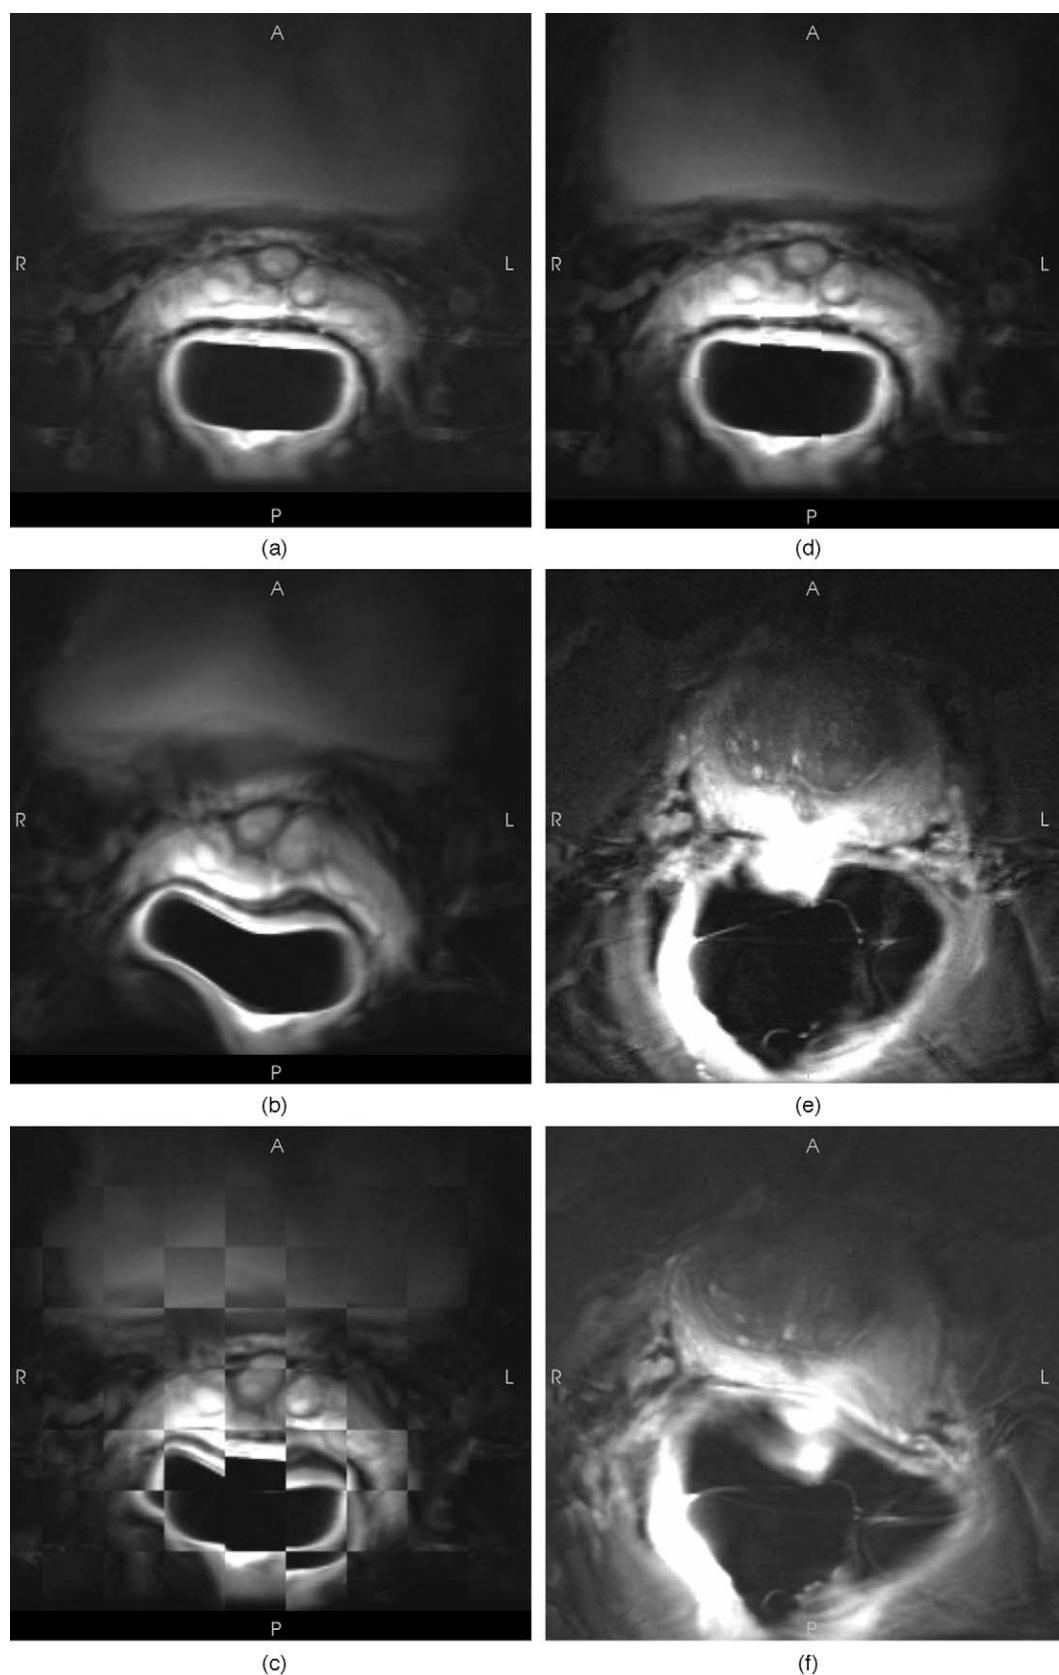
Checkerboard visualization of algorithm's capability to recover from intentionally introduced deformations for two cases. The test is to register the warped image to the "gold standard" represented by the original form of the deformed magnetic resonance image. For the first case, the original and intentionally deformed images are shown in (a) and (b), respectively. The checkerboard images before and after deformable registration are shown in (c) and (d), respectively. The registration process and the results for the second case are shown in (e) to (h). Figure continues on p. 599.
